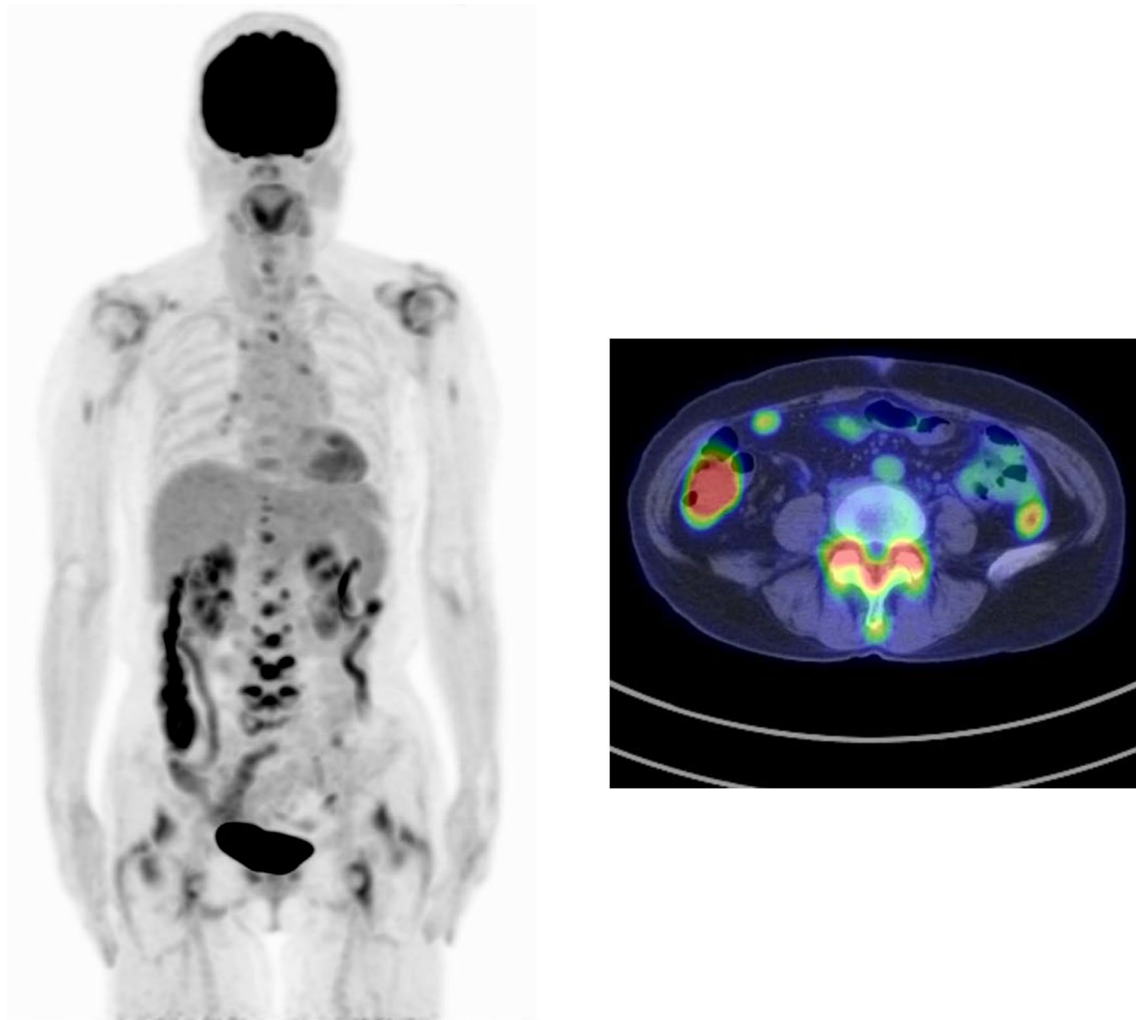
^{18}F -FDG PET/CT images of a 67-year-old female with PMR. PET/CT reveals abnormal accumulation in the shoulders, the ischial tuberosity, vertebral spinous processes, and iliopsoic bursa. There is the “Y-shaped uptake” pattern in the spinous processes
